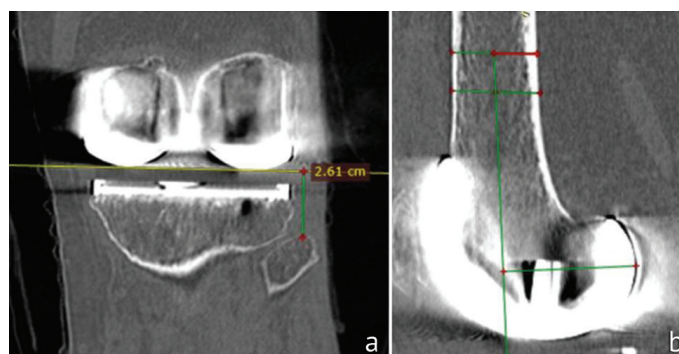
Postoperative CT scan of the knee: (a) frontal view; (b) sagittal projection
